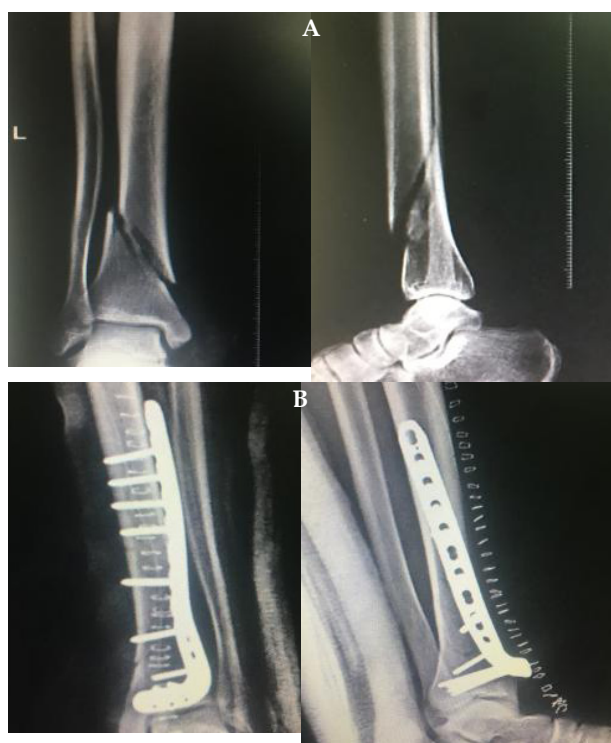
A: pre-op X-ray left leg AP and lateral view. B: post-op X ray left leg AP view and lateral view.
